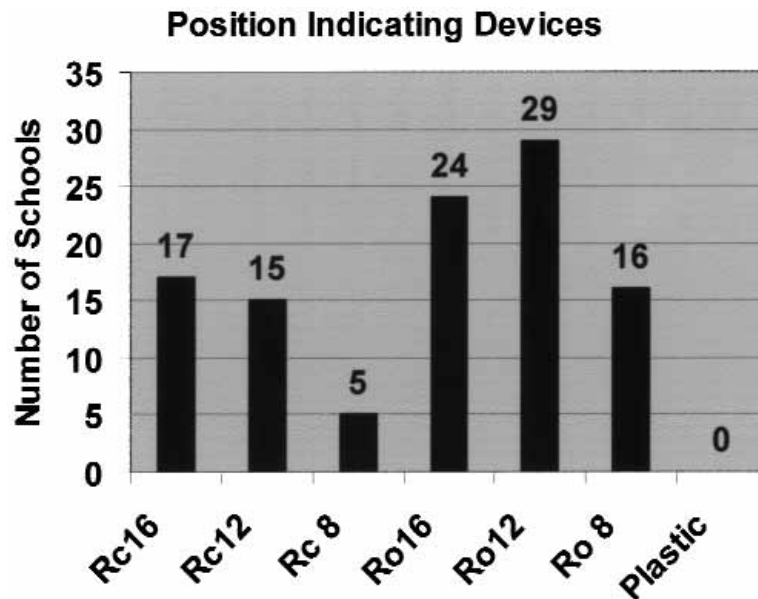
Lengths and shapes of position indicating devices for intraoral radiography. (Rc 16, 16-in rectangular; Rc 12, 12-in rectangular; Rc 8, 8-in rectangular; Ro 16, 16-in round; Ro 12, 12-in round; Ro 8, 8-in round.)
